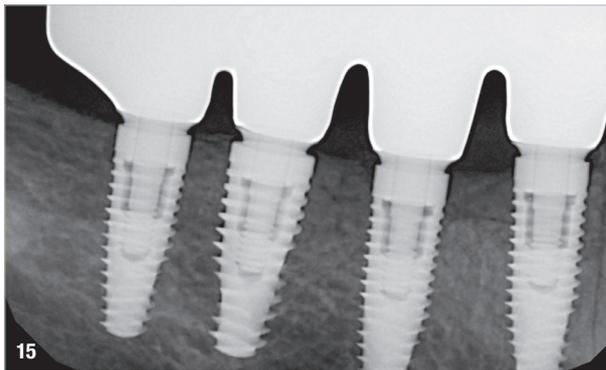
Radiograph taken at six months after implant insertion. Fig. 16: Follow-up at 12 months post-op.
